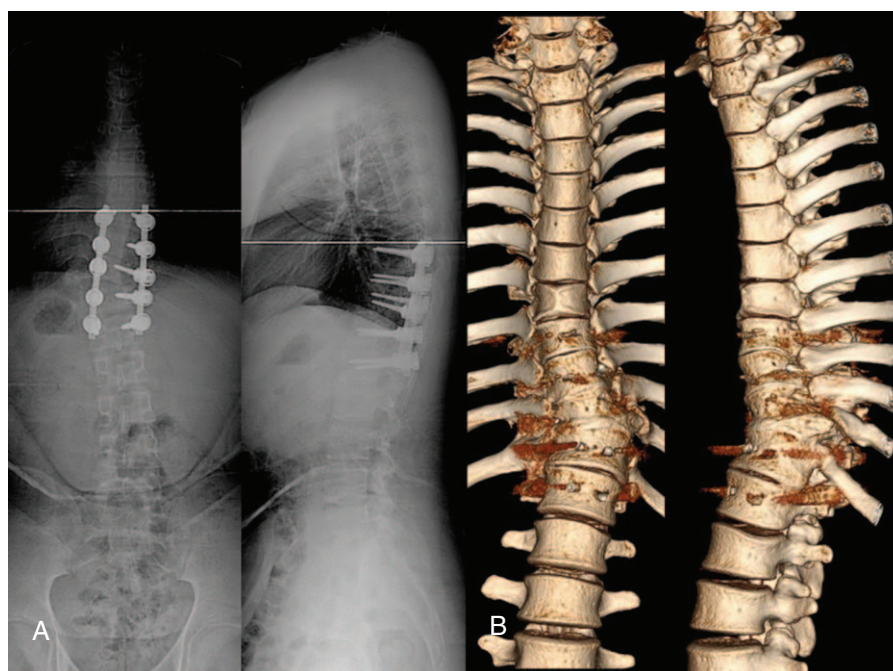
(A) Radiographs taken before implant removal showing that the main scoliotic curve was maintained at  $28^\circ$  at a 4-year follow-up. (B) Six-month follow-up radiographs after implant removal showing that the main scoliotic curve was maintained at  $31^\circ$  without curve progression.
